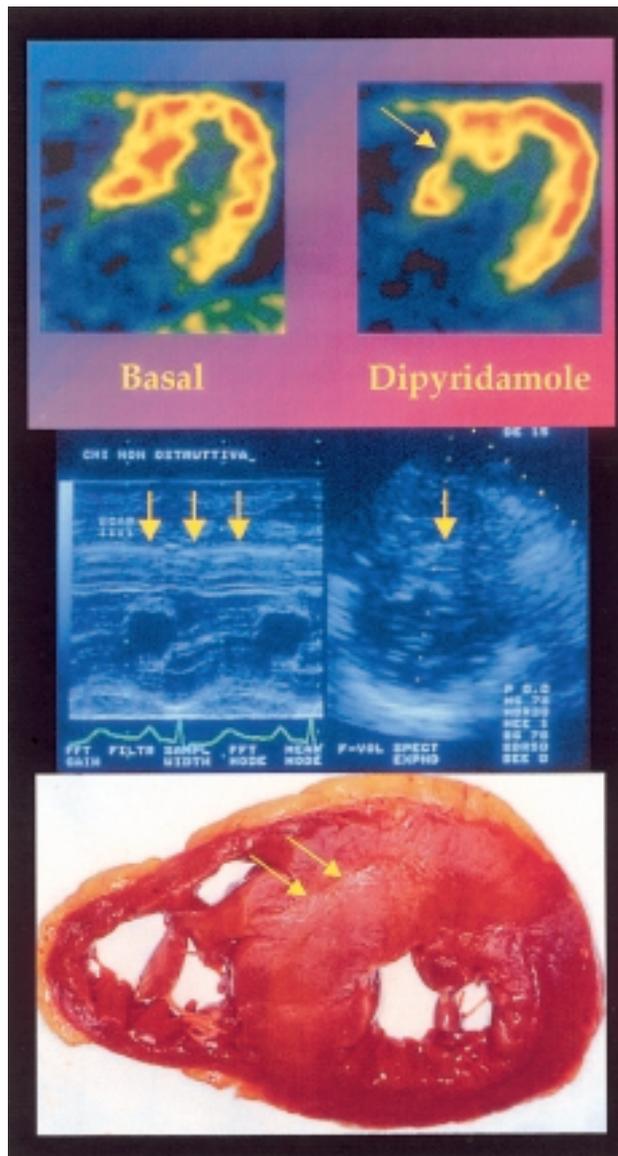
Septal hypoperfusion and scarring in a male patient with non-obstructive hypertrophic cardiomyopathy. Top panel: positron emission tomography scan (at age 43) showing myocardial perfusion at basal conditions and following dipyridamole infusion. After dipyridamole, a well-defined area of hypoperfusion is evident in the interventricular septum (arrow). Middle panel: echocardiographic parasternal short-axis view (at age 43), showing a hypertrophic, structurally irregular interventricular septum; the hyperechogenic area within the septal wall was suggestive of intramyocardial fibrosis and interpreted as scarring (arrows). Bottom panel: following the death of the patient at 46 years of age due to progressive heart failure, autopsic examination of the heart documented the presence of a translucent area of replacement fibrosis secondary to myocardial ischemia within the hypertrophied anterior septum (arrows).
